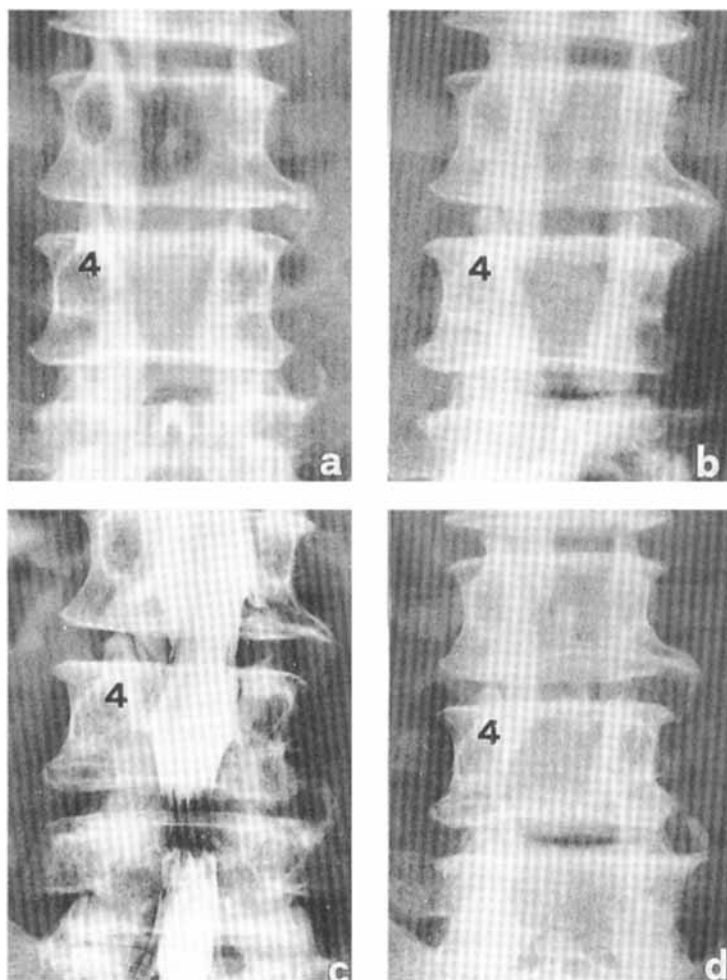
In this patient, submitted to total laminectomy at L3 to L5, decompression was too narrow at L4-L5 (a). 3 years after surgery, anteroposterior radiograph revealed regrowth of the posterior arch at L4-L5 (b); 4 years following the initial surgery a myelogram (c) revealed recurrent stenosis at L4-L5 and repeat decompression (d) was performed at this level.
